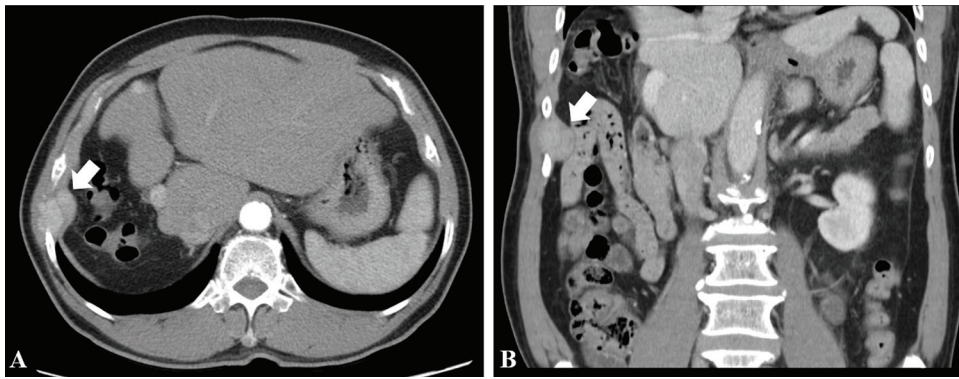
Axial (A) and coronal view (B) of contrast-enhanced CT scan showed an arterial enhancing nodule involving chest wall and peritoneum, sized 2.2 cm.
